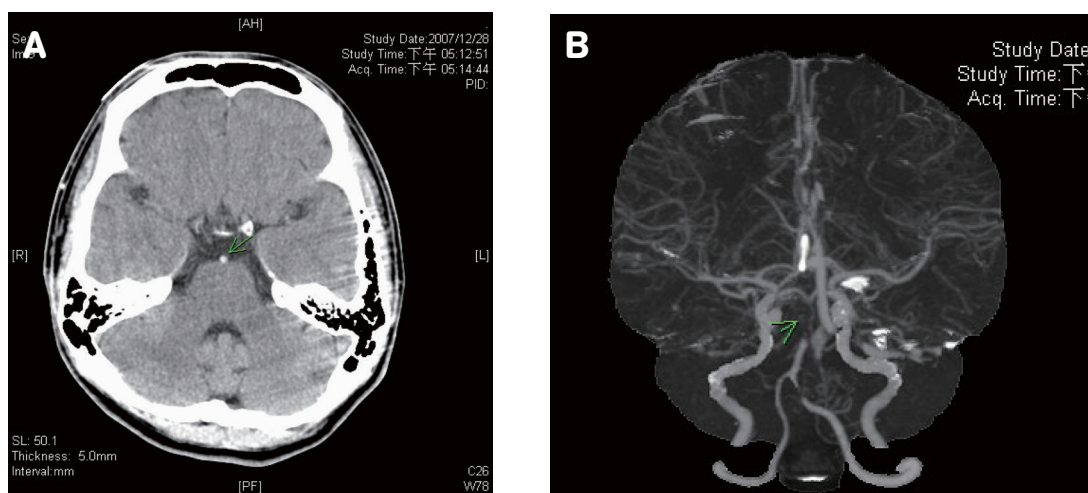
Axial CT (A) reveals hyperdense acute thrombus (arrow) in the basilar artery. CT angiography (B) shows occlusion of the basilar artery at its middle third (arrow) and the bilateral posterior cerebral arteries are unoccluded.
